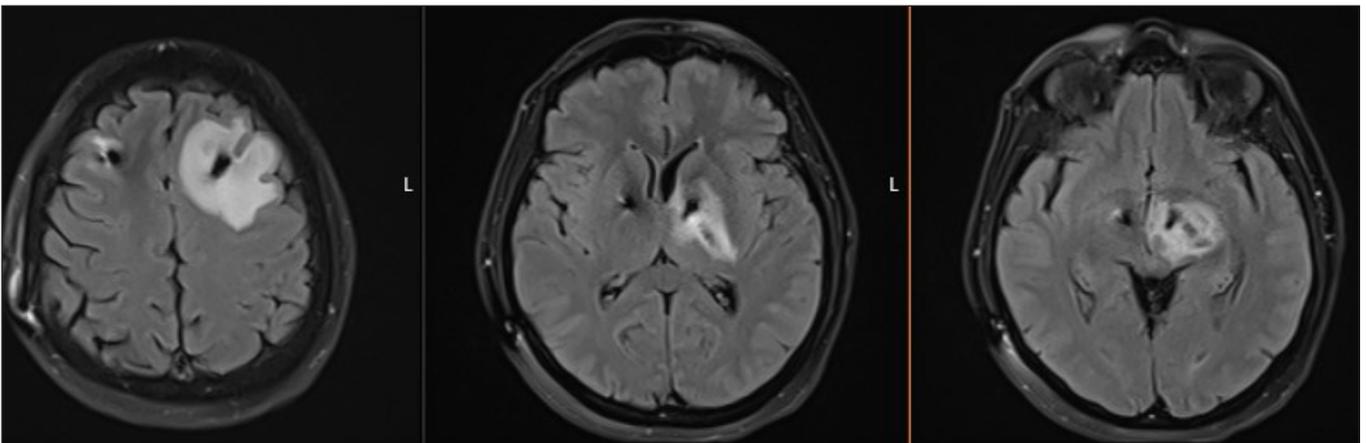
T2 Flair MRI depicting hyperintensity in the left frontal lobe, the left lentiform nucleus, capsular interna, and left section of the mesencephalon.
